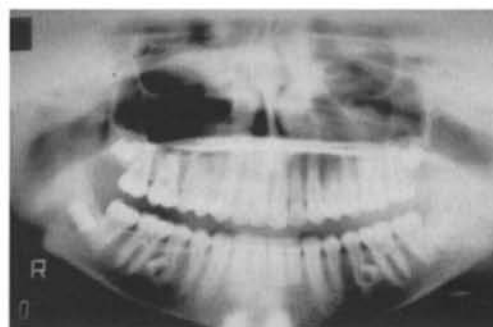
Orthopantomagram (OPG) showing late development of supernumerary mandibular second premolars.
